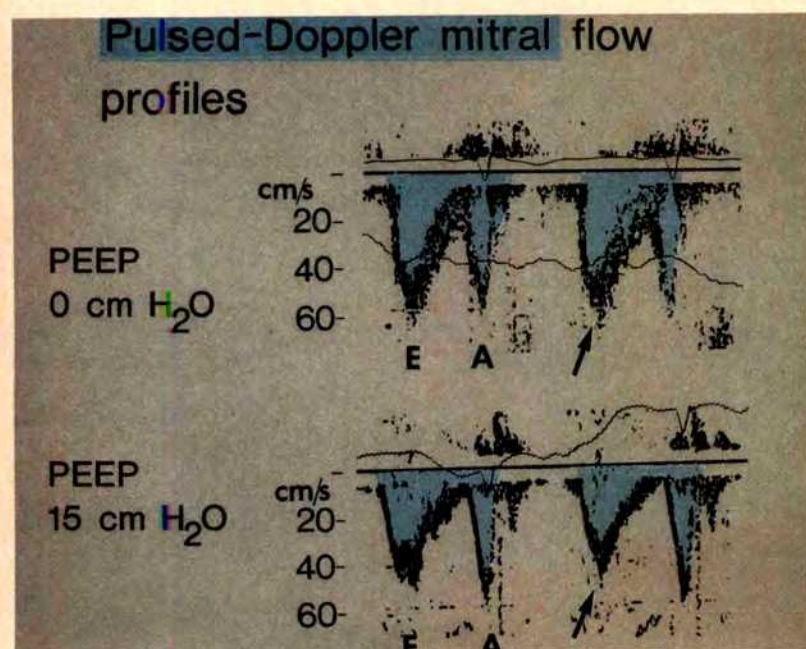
The pulsed Doppler mitral flow profile is shown for 0- and 15-cm H₂O positive end-expiratory pressure (PEEP). Arrow indicates that there is mainly a reduction of the E wave with induction of PEEP.
